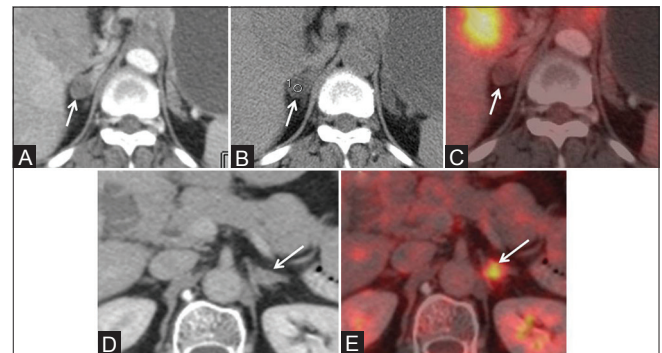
(A-E): Adrenal adenoma versus metastasis. Enhancing solid adrenal nodule on CT scan in a case of lung cancer (arrow, A) suggestive of metastatic deposit. Unenhanced CT scan shows fatty attenuation within the nodule with an HU value of 0 suggesting the possibility of an adenoma (arrow, B). FDG PET/CT shows no tracer concentration in the nodule, confirming the diagnosis of adenoma. Enhancing solid adrenal nodule on CT scan in another patient of lung cancer (arrow, D), which is indeterminate in nature. FDG PET/CT shows abnormal focal tracer concentration in the nodule (arrow, E) highly suggestive of a metastatic deposit
